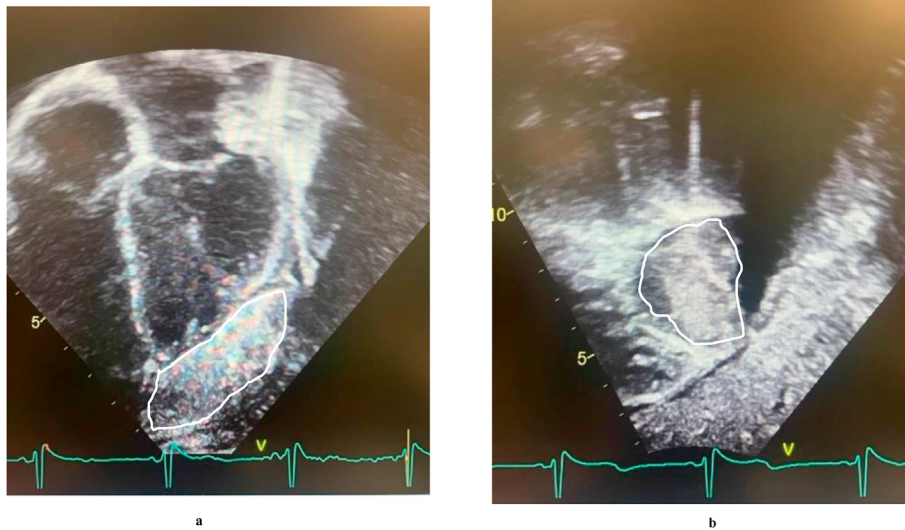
a,b: Echocardiography with a parasternal long axis view and of left ventricular free wall fibroma(fibroma outlined in white).
